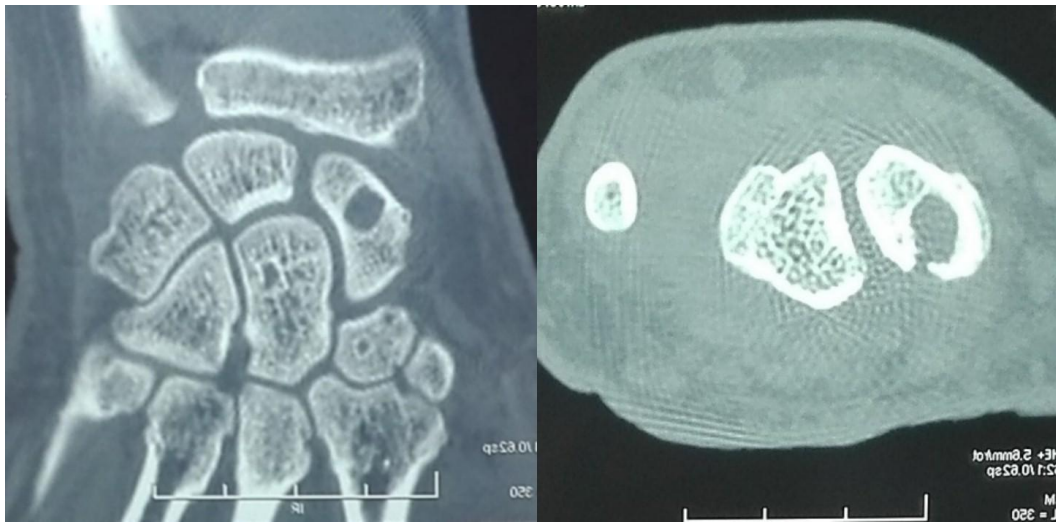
CT-scan showing the lucent area with a sclerotic margin within the scaphoid, communicating with the joint space. The other carpal bones and soft tissue were normal
